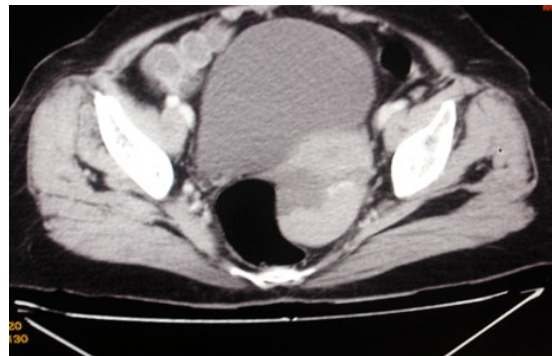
Abdominopelvic CT scan showing Left ovarian mass with solid cystic component.
